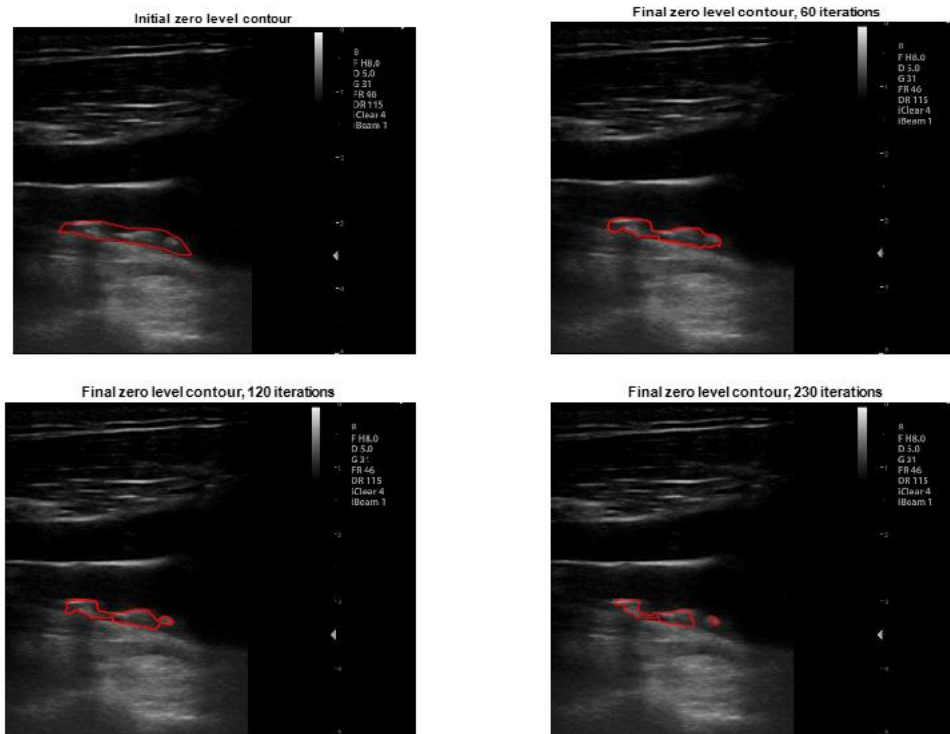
Level set method results on one ultrasound video
